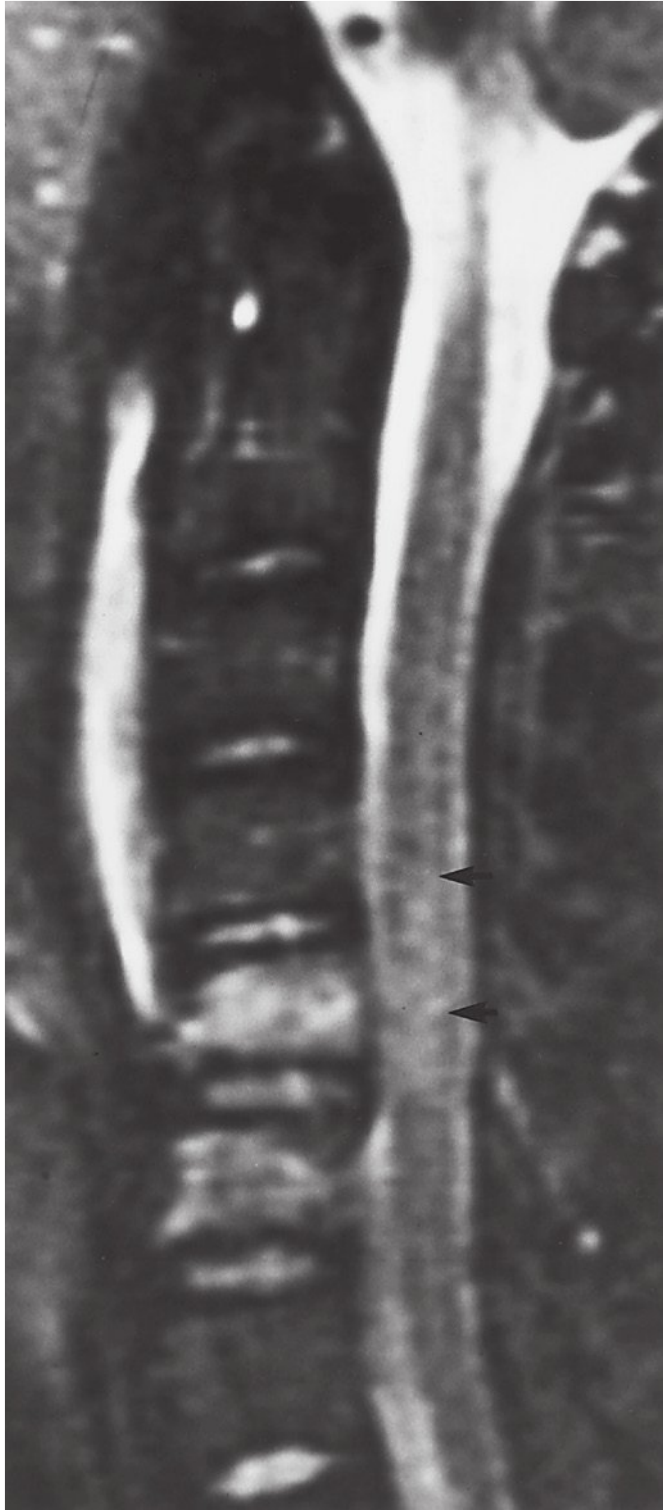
T2-weighted magnetic resonance imaging demonstrating increased signal intensity suggestive of spinal cord edema. (Reproduced from Uhlenbrock D. MR Imaging of the Spine and Spinal Cord. Stuttgart, Germany: Georg Thieme Verlag; 2004: Fig. 7.6, with permission.)
